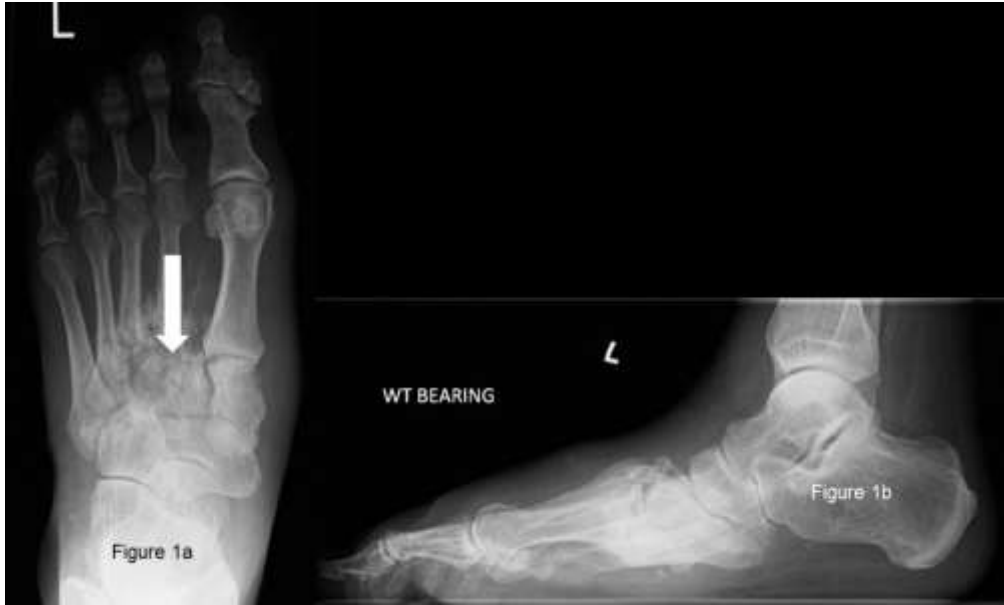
Left foot AP and lateral radiograph demonstrating midfoot collapse, widening of the 1st and 2nd MT interspace.
